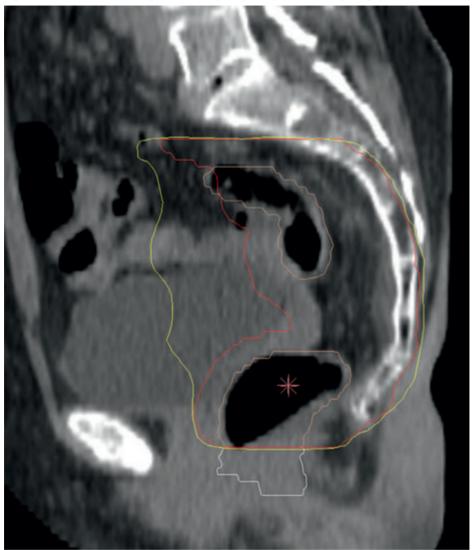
Delineation of anal sphincter complex (white) and rectum (orange) on CT scan.
